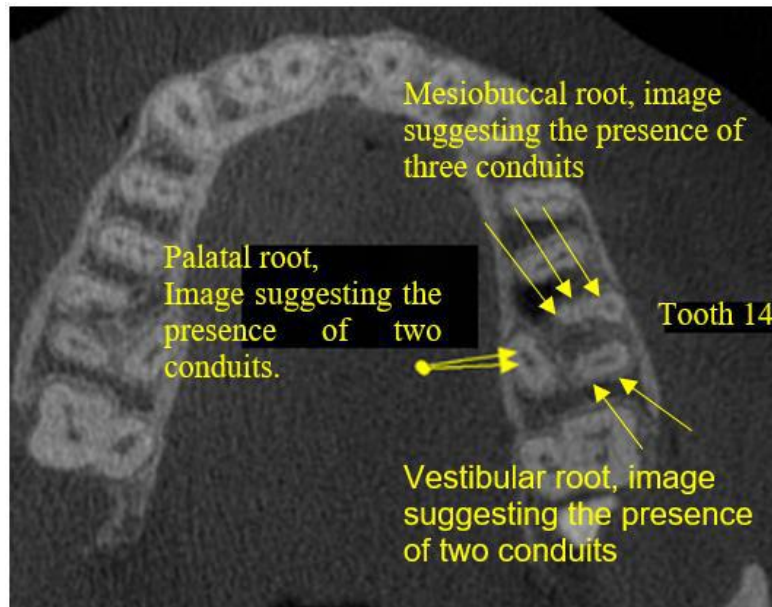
Computed tomography for root canal evaluation
